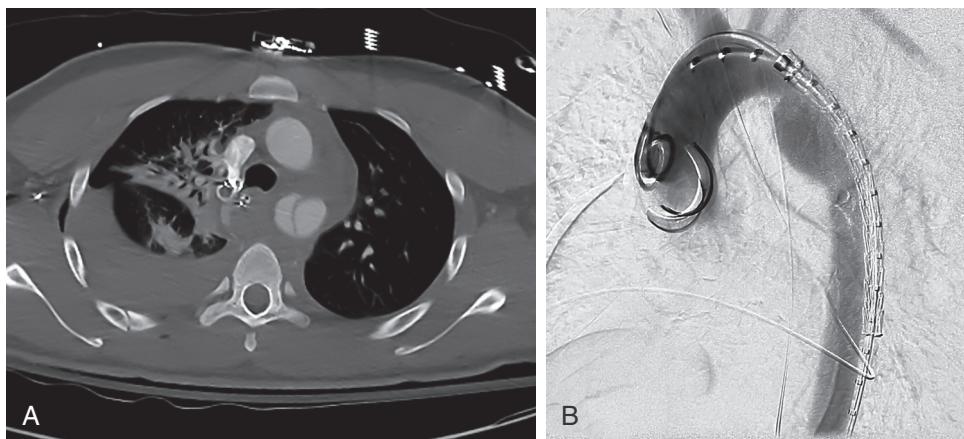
Blunt Aortic Injury. (A) CT angiogram demonstrating type III blunt aortic injury with pseudoaneurysm. (B) Conventional angiography demonstrating an aortic pseudoaneurysm immediately prior to TEVAR.
